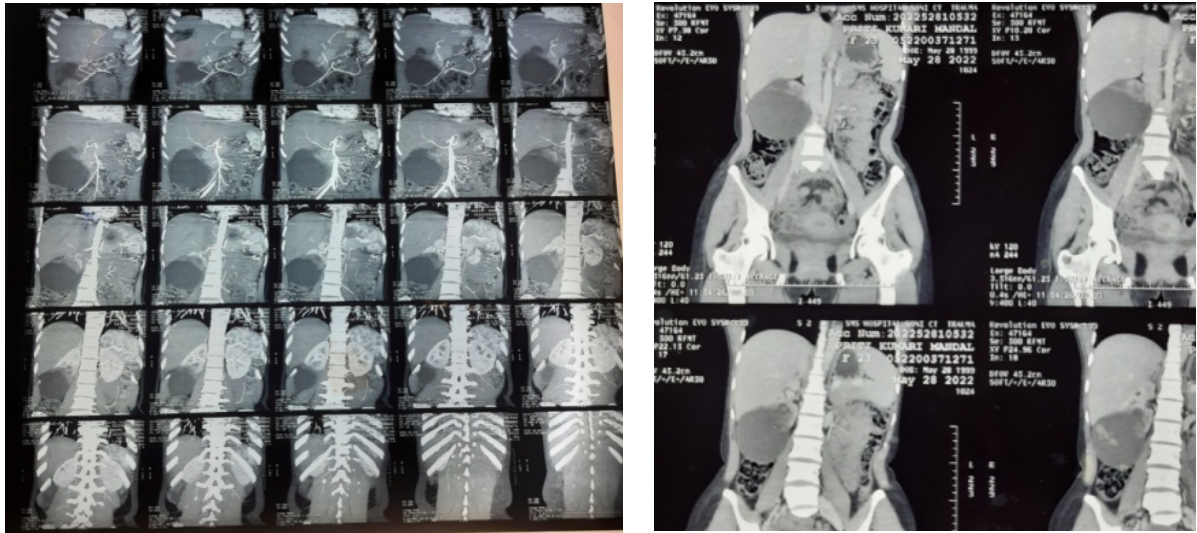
(A & B): On CT scan – Approx 98x86 mm size cyst in lower pole of right kidney showing no contrast enhancement, suggestive of right renal cortical cyst.
